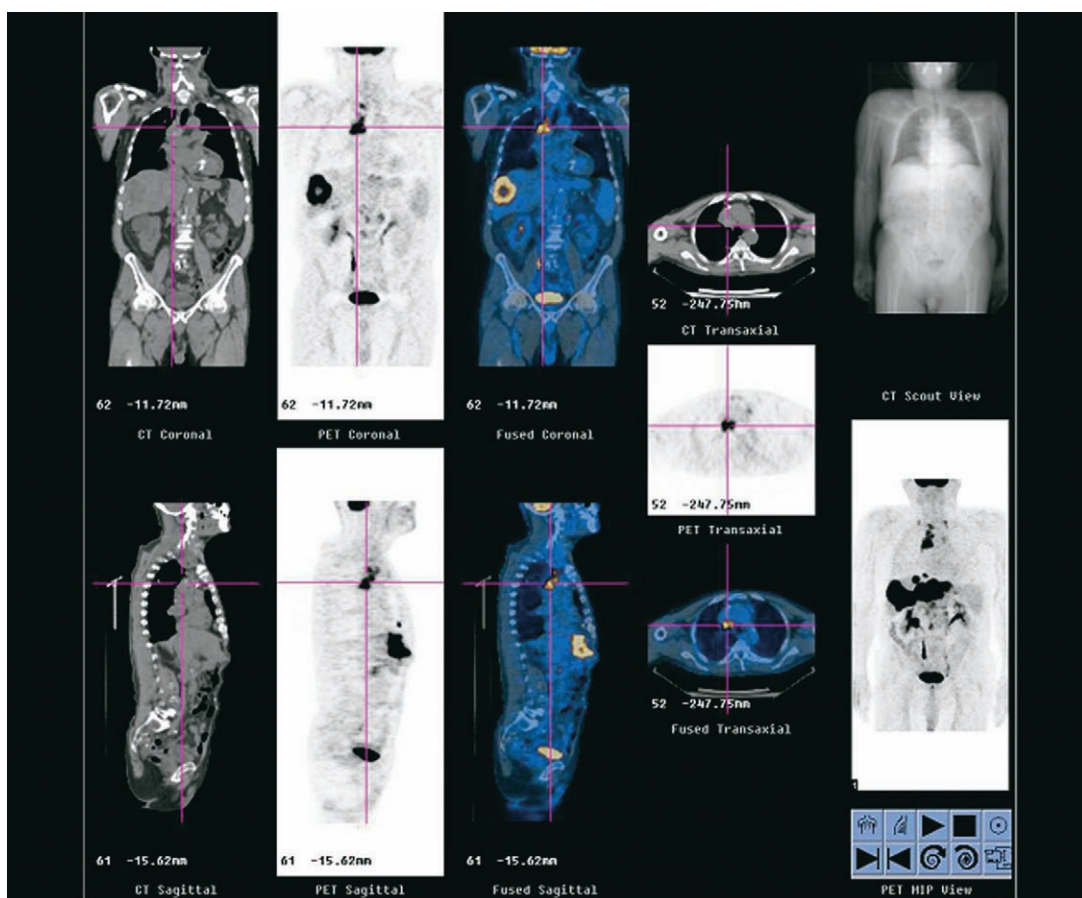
$^{18}\text{F}$ FDG-PET, CT, and fusion images from a 73-year-old man who had a history of colon carcinoma that was resected 4 years earlier followed by a course of chemotherapy. The patient now has an elevated serum carcino embryonic antigen (CEA) value and suspicion of a mediastinal mass. A hypermetabolic (increased  $^{18}\text{F}$ FDG) mass is seen in the right anterior mediastinum and a large mass is seen in the liver. These findings are metastatic colon carcinoma. The chest mass is indistinguishable from a second primary neoplasm. (Courtesy of Division of Nuclear Medicine, Department of Radiology, New York Presbyterian Hospital, Weill Cornell Medical Center, New York, NY).
